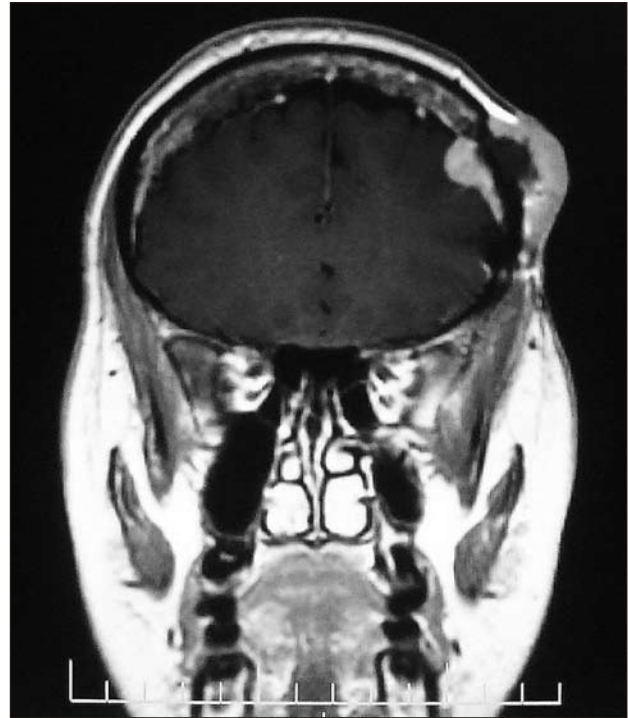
Magnetic resonance image, coronal view, showing the previous craniotomy site and a soft tissue density with intracranial and subcutaneous components.
